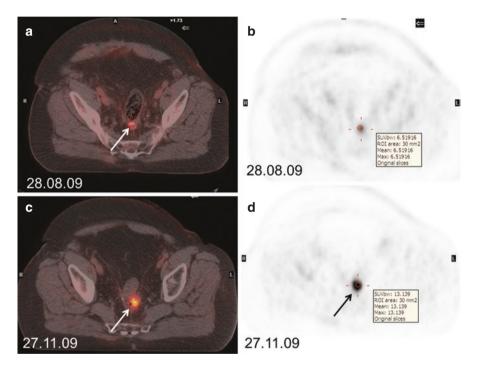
Role of FDG PET-CT in recurrent colorectal cancer. 75-year-old male with sigmoid adenocarcinoma treated with anterior resection. A FDG PET-CT was performed prior to surgical resection of a small liver lesion. Axial fused PET-CT image (a) and attenuated corrected image (b) demonstrated a focus of intermediate intensity uptake at the anastomotic margin (arrows). At that point (approximately 6 months post-surgery) it was not clear if this was persistent inflammatory uptake or recurrence. Follow up PET-CT 3 months later demonstrates persistent focal high intensity uptake increased compared to previous located eccentrically at the anastomotic line consistent with recurrent disease (arrows in c and d) which was subsequently confirmed on sigmoidoscopy. Early recurrence at the anastomotic line can be difficult to accurately characterize on conventional imaging modalities
